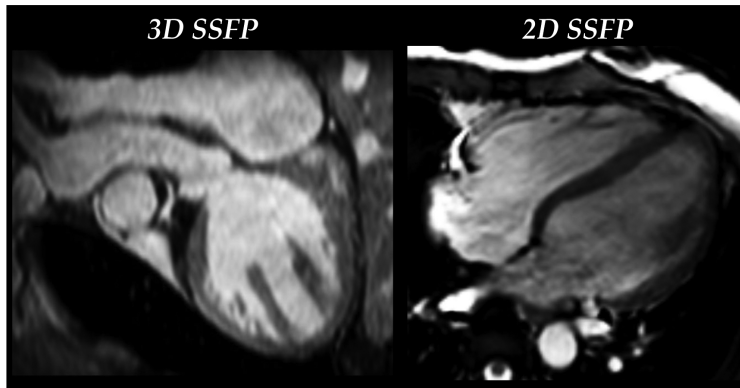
MRI images acquired with a 3D isotropic SSFP sequence (coronal view) and a 2D non-isotropic SSFP sequence (long-axis view). Both images belong to the same subject.
